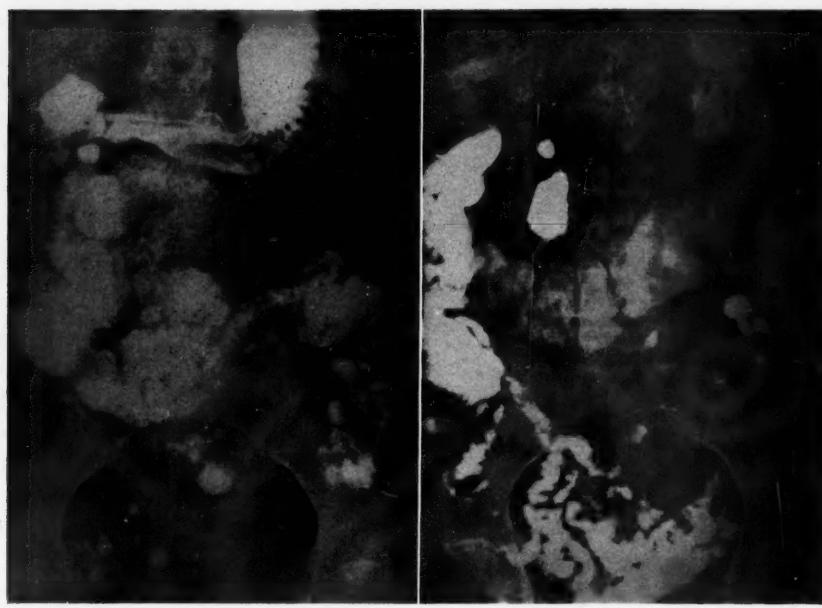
Case 1. A, Upper gastrointestinal x-ray showing jejunal diverticula; B, one-hour film again shows the diverticula.
